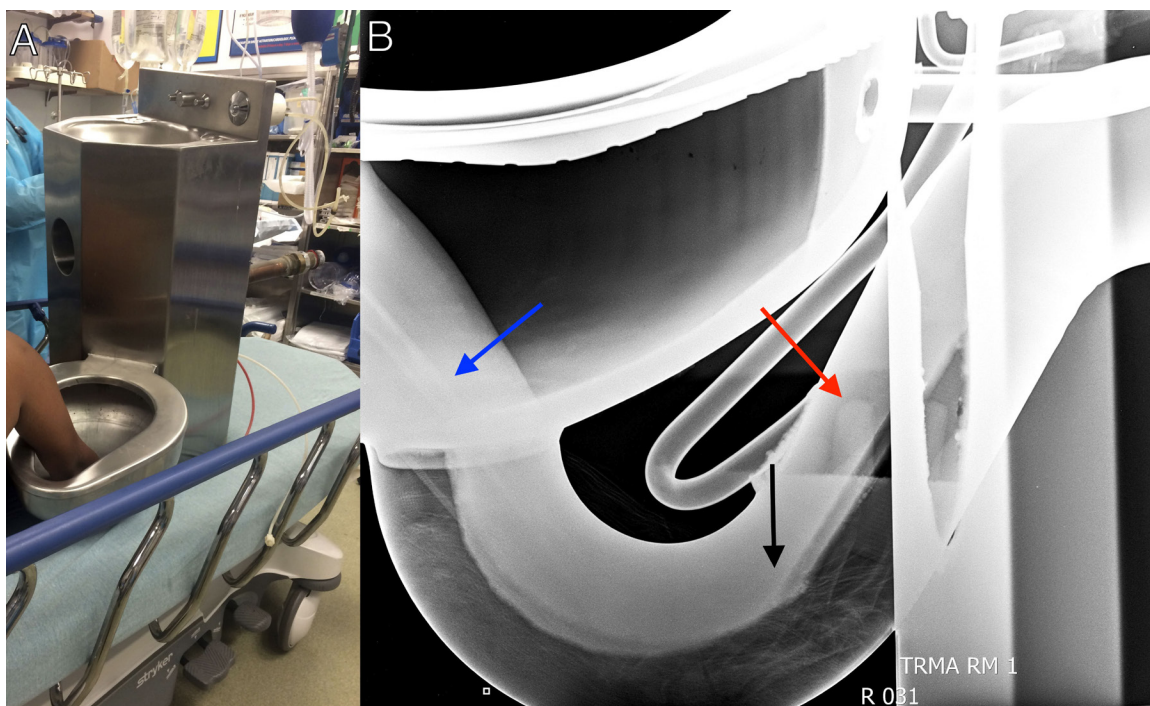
The patient’s right hand and intact sink / toilet assembly (Panel A) on the stretcher in the trauma bay; the lateral view radiograph of the entrapped hand (blue arrow – shaft of radius; black arrow – metacarpals; red arrow – distal tips of fingers) inside the toilet (Panel B).
